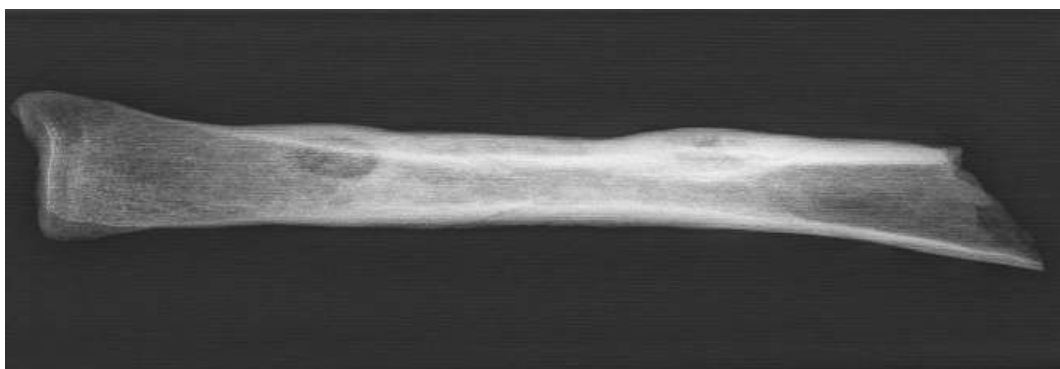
X-ray image of the tibia
